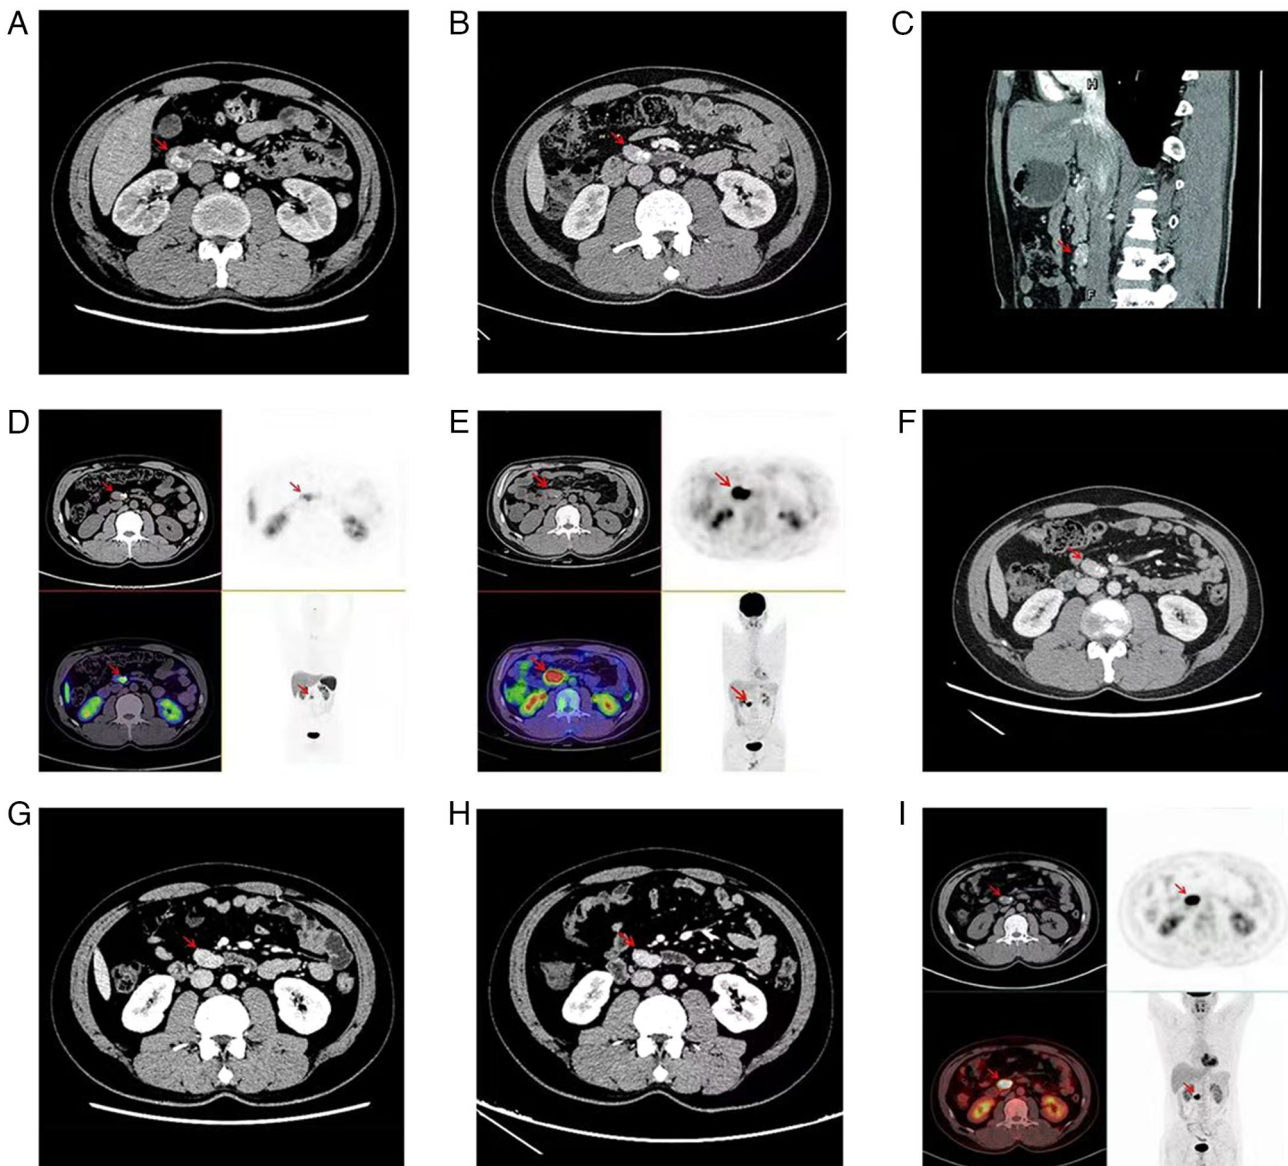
Imaging results of the duodenal mass corresponding to the present case report. (A) Abdominal enhanced CT (March 2020) showing a modest enhancement on enhanced scanning and a soft tissue mass in the descending section of the duodenum $\sim 2.7 \times 2.4$ cm in size (arrow). (B) Transverse plane and (C) Sagittal plane abdominal enhanced CT (June 2020) showing a mass of 2.8×1.9 cm in the horizontal section of the duodenum, which could be a recurrence of duodenal gangliocytic paraganglioma (arrows). (D) ^{68}Ga -Dotatate and (E) ^{18}F -FDG PET-CT (June 2020) revealed a focus of considerably increased FDG uptake of $\sim 2.9 \times 1.9$ cm in size (arrows). Punctate calcification was observed inside, as well as elevated ^{68}Ga uptake above the horizontal section of the retroperitoneal duodenum, suggesting possible metastasis or recurrence. (F-H) Abdominal enhanced CT on (F) September 2020, (G) February 2021 and (H) February 2024 revealed that the mass's size was hardly altered compared with the previous scan (arrows), and the enhancement scan showed limited enhancement. (I) PET-CT on February 2024 revealed a nodule with enhanced FDG metabolism, measuring $\sim 2.9 \times 1.8$ cm and located above the duodenum (arrows). CT, computed tomography; PET, positron emission tomography; FDG, fluorodeoxyglucose.
